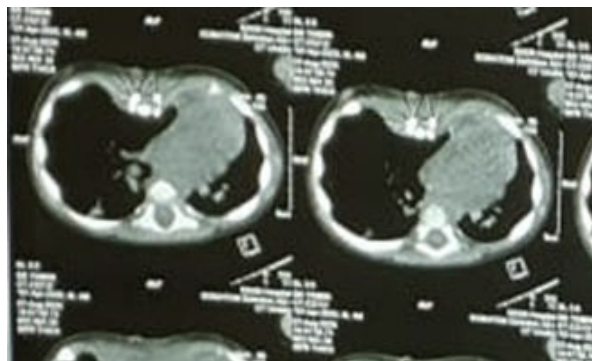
Post-operative CT scan: demonstrating improvement
